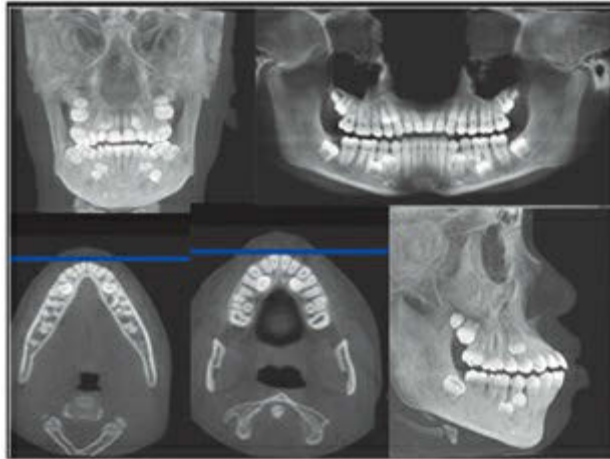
Different CT scans of a patient with oligodontia.
